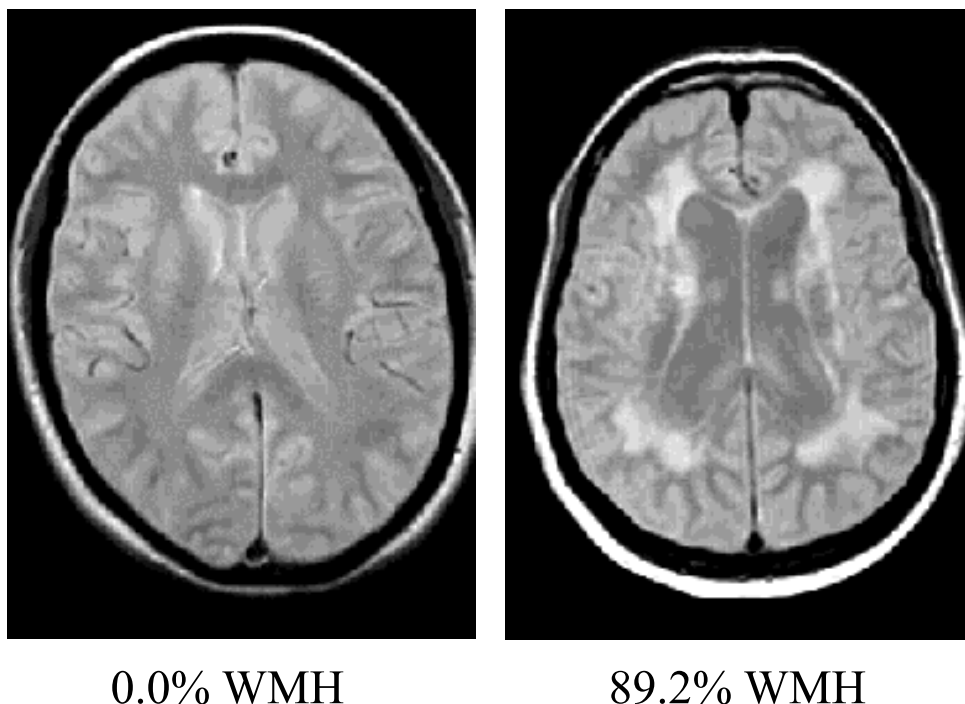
Axial proton-density MR images for two individuals with different percentages of white matter signal hyperintensities (WMH).
